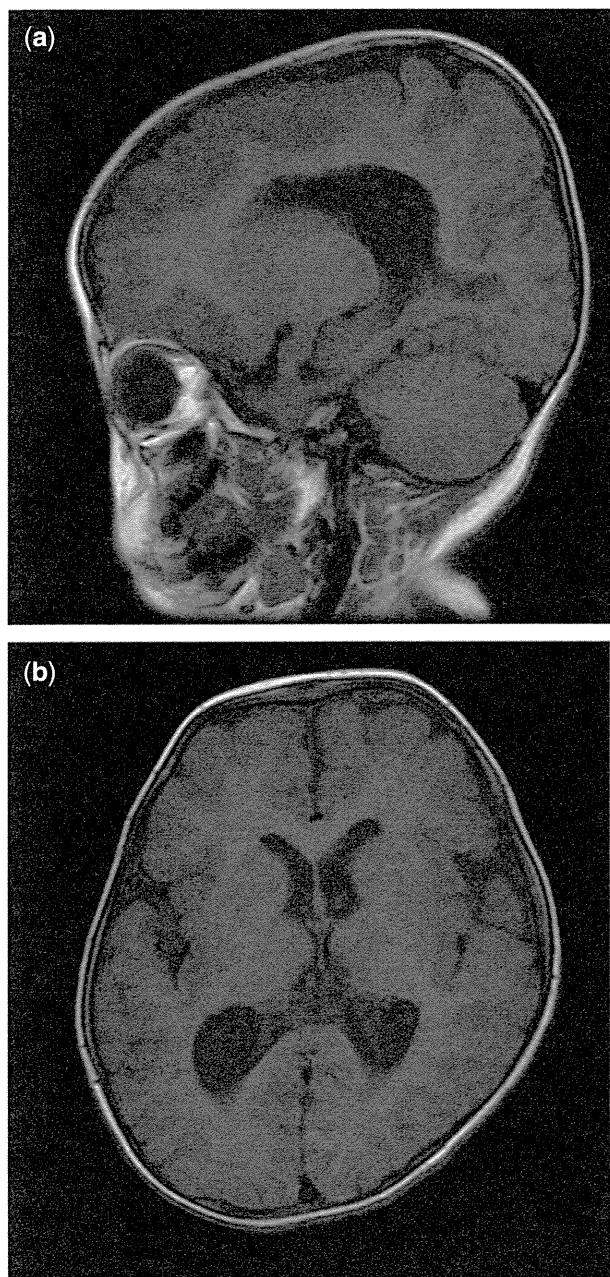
(a, b) T1-weighted magnetic resonance image (MR) of patient 1 with *ACTB* mutation shows enlarged lateral ventricles, decreased white matter volume and pachygyria dominant in the frontal lobe.
